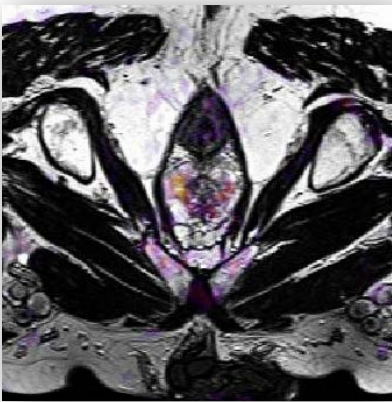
RSI-MRI imaging performed at UTHSCA Research Imaging Institute. Yellow/Red indicates high suspicion of tumor.
